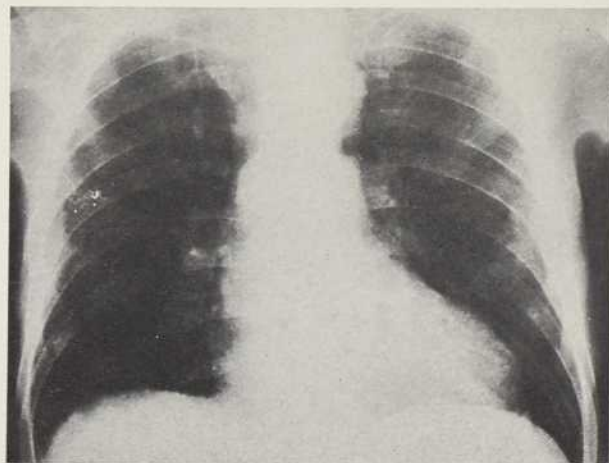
X-ray chest 1 month after operation (patient W.K.) shows a virtually normal-sized donor heart, an arteriosclerotic elongated recipient's aorta and clear lungs.
